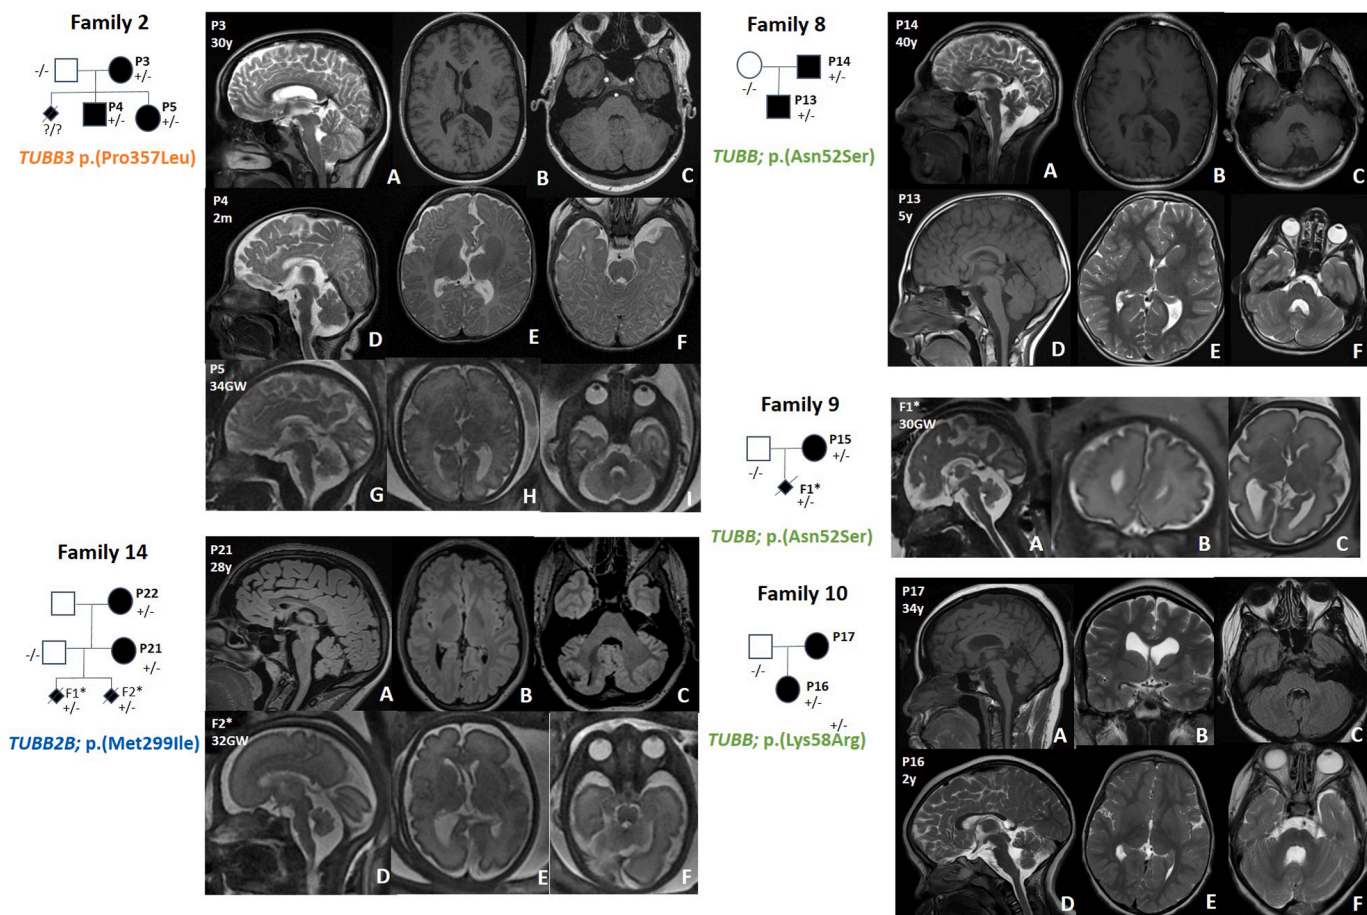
Brain magnetic resonance imaging of inherited form of mild tubulinopathies. Family 2 (P3, P4, and P5): the sagittal slices (A, D, G) show reduced anteroposterior diameter of the pons (<5th percentile) with abnormal bulging and dysgenetic corpus callosum; the axial slices (B, C, E, F, H, I) reveal midline distortion and dysmorphic and fused basal ganglia, asymmetry of the lateral ventricles, dysmorphic frontal horns, and brainstem asymmetry. Family 14 (P21 and F2*: index case [fetus, termination of pregnancy (TOP)], not included in the study): the sagittal slices (A, D) show reduced anteroposterior diameter of the pons (<5th percentile) with abnormal bulging; the axial slices (B, C, E, F) reveal midline distortion, right fused basal ganglia (B), dysmorphic (E) and asymmetric lateral ventricles (E), and brainstem asymmetry. Family 8 (P14 and P15): the sagittal slices (A, D) show reduced anteroposterior diameter of the pons (<5th percentile) with abnormal bulging and dysgenetic corpus callosum; the axial sections (B, C, E, F) reveal midline distortion and dysmorphic and fused basal ganglia, asymmetry of the lateral ventricles, dysmorphic frontal horns, and brainstem asymmetry. Family 9 (P15 and F1*: index case [fetus, TOP] not included in the study): the sagittal, coronal, and axial slices (A, B, C) show reduced anteroposterior diameter of pons (<5th percentile), midline distortion, dysmorphic and fused basal ganglia, asymmetry of the lateral ventricles, and dysmorphic frontal horns. Family 10 (P17 and P16): the sagittal slices (A, D) show reduced anteroposterior diameter of pons (<5th percentile) with abnormal bulging and dysgenetic corpus callosum (D); the axial (C, F, E) and coronal slices (B) reveal mild midline distortion, dysmorphic and fused basal ganglia, asymmetry of the lateral ventricles, dysmorphic frontal horns, and brainstem asymmetry. Family 10 (P17 and P16): Sagittal sections (A, D) show an abnormal anteroposterior diameter of the pons (<5th percentile), a similarly abnormal bulging, and a dysgenetic corpus callosum (D); axial (C, F, E) and coronal sections (B) reveal a slight midline distortion, dysmorphic and fused basal ganglia, asymmetry of the lateral ventricles, dysmorphic frontal horns, and brainstem asymmetry. The color version of this figure is available in the online edition.
